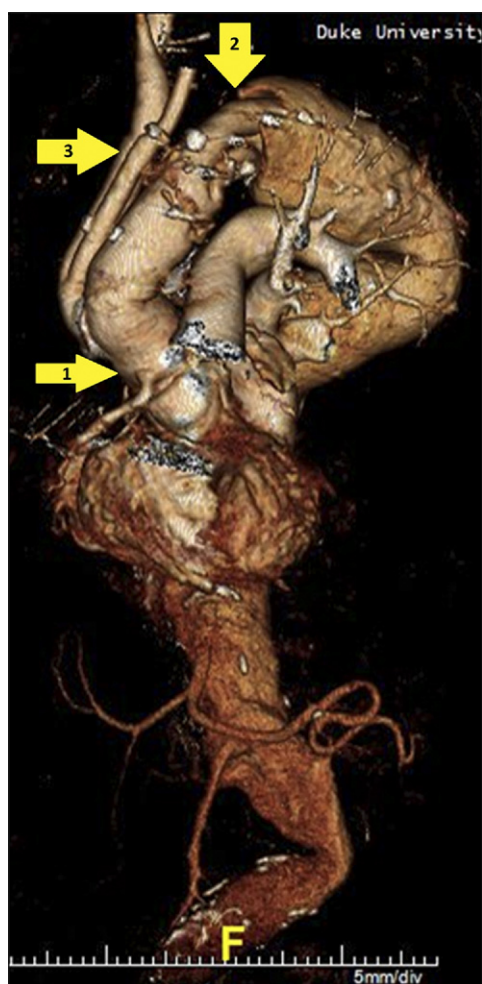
Three-dimensional reconstruction computed tomography angiography after stage I repair demonstrating intact aortic root (*arrow one*) and total arch replacement with elephant trunk (*arrow two*). The innominate and left common carotid arteries have been individually reimplemented into a multi-branch Dacron graft (*arrow three*); the left subclavian artery has been ligated proximally and bypassed distally (*patent bypass not included in image field of view*) to exclude the symptomatic subclavian aneurysm. Note residual distal arch/Extent II thoracoabdominal aortic aneurysm (TAAA).
